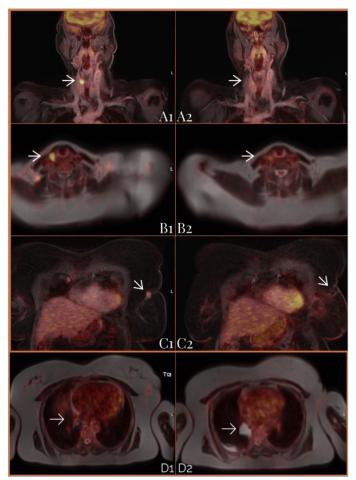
Comparison of PET MRI images before and after treatment. A1, B1, FDG uptake in right thyroid tissue; A2, B2, regressed lesion post-treatment. C1, FDG uptake in the upper outer quadrant of the left breast; C2, postoperative changes. D1, FDG uptake mass with extension in the mediastinum-paraesophageal region in the medial basal segment of the right lower lobe of the lung; D2, postoperative atelectatic changes.
